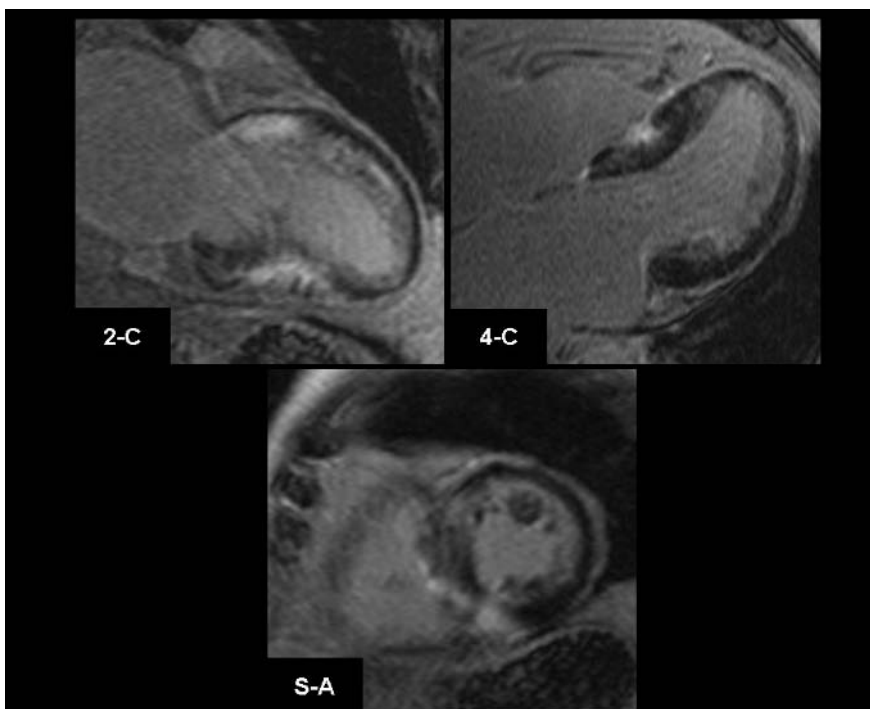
Myocardial scarring in hypertrophic obstructive cardiomyopathy (MRI). Two-chamber (2-C), four-chamber (4-C), and mid short-axis (S-A) delayed enhancement images demonstrate patchy myocardial scarring (bright) intermixed with more normal-appearing myocardium (dark). The non-subendocardial distribution of the scarring within the hypertrophic left ventricle with asymmetric septal prominence is characteristic of non-ischaemic myocardial disease
